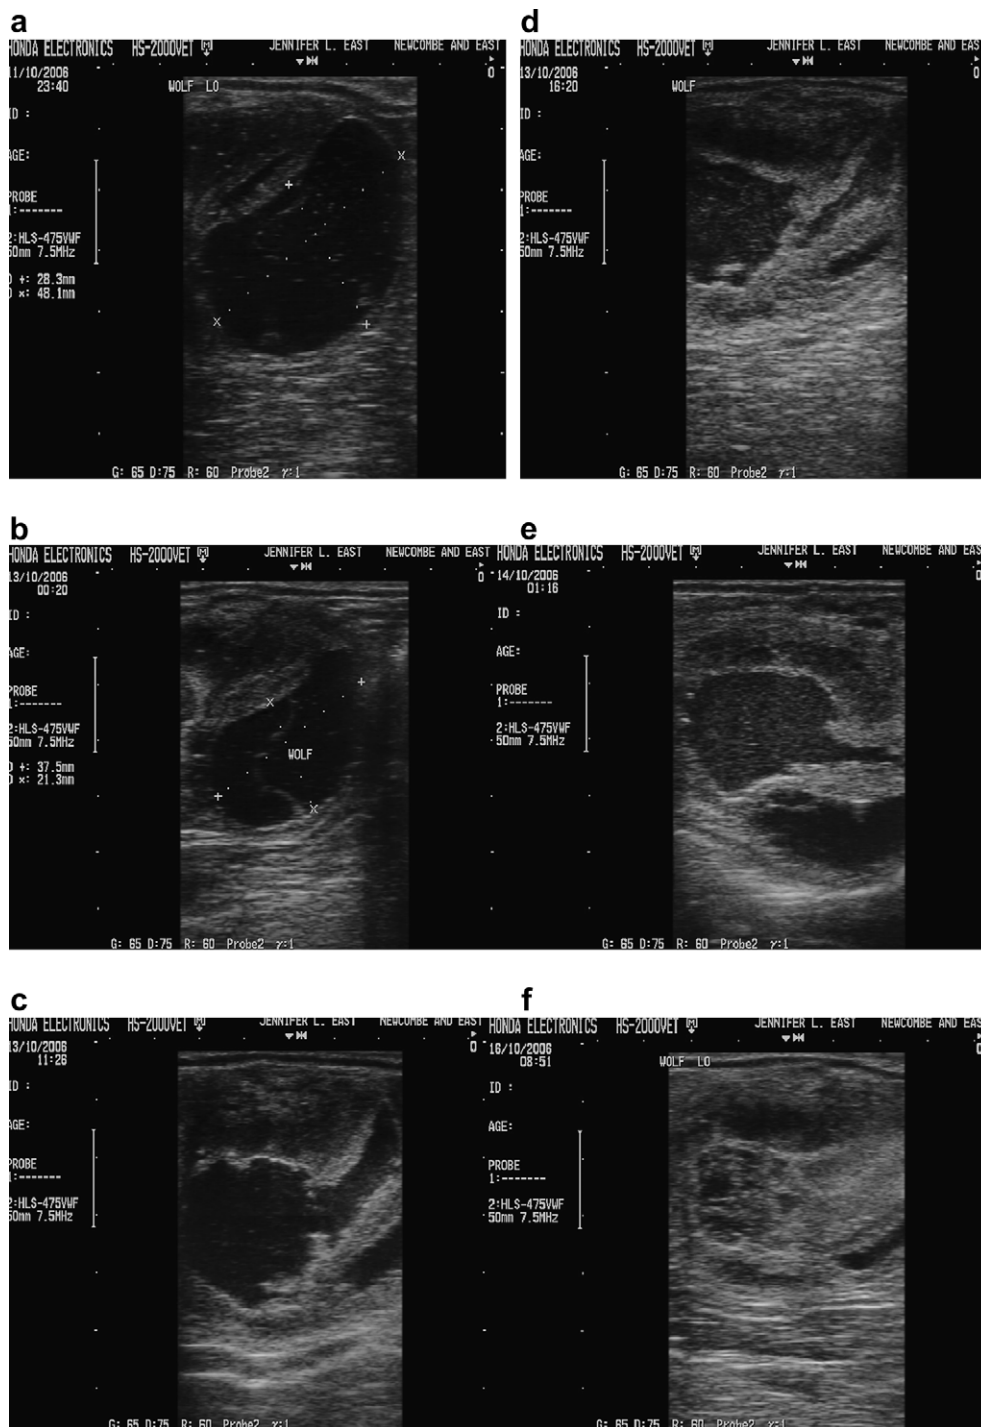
Chronological order of a sonogram series of a follicle that collapsed partially with substantial loss of follicular fluid with subsequent hemorrhage and luteinization; (a) preovulatory-sized follicle with some degree of hemorrhage (hyperechoic specks); (b) reduction in follicular diameter as a result of partial loss of follicular fluid; (c) and (d) the partially collapsed follicle is further divided in follicular compartments, follicular wall thickens and becomes hyperechoic as a result of luteinization; (e) hemorrhage becomes more apparent; (f) follicular contents organize acquiring static appearance. (a) Hour 0 (beginning of hemorrhage); (b) + 24 hours; (c) + 35 hours; (d) + 40 hours; (e) + 49 hours; (f) + 105 hours.
